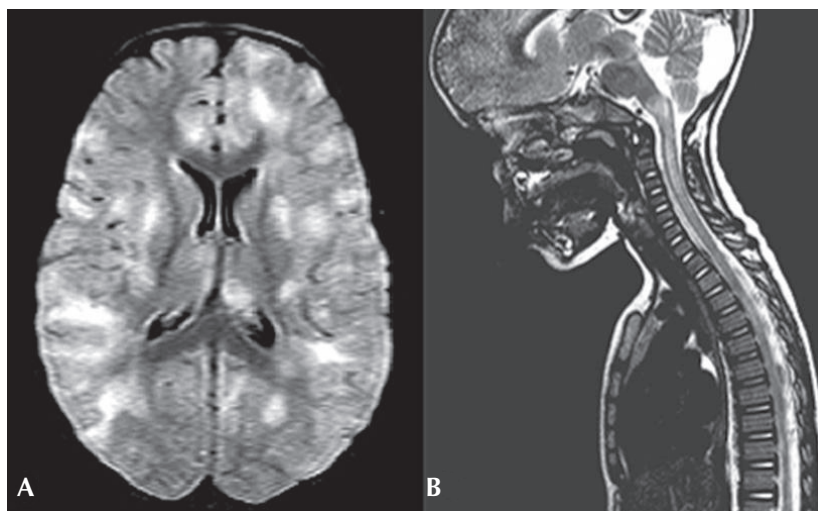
(A) An axial fluid-attenuated inversion recovery magnetic resonance imaging (MRI) of the brain in a child with acute disseminated encephalomyelitis demonstrates multifocal areas of hyperintensity in both cerebral hemispheres involving cortical gray matter, centrum semiovale, and deep gray nuclei. (B) A saggital T2-weighted MRI of the spine in the same child demonstrates high signal intrinsic to the spinal cord, consistent with longitudinally extensive transverse myelitis.
